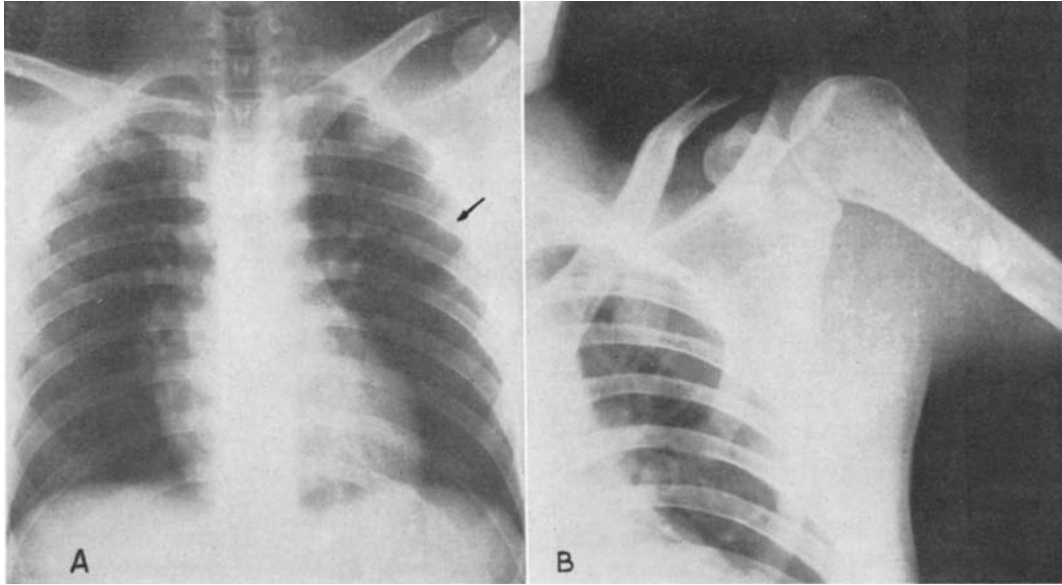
This patient was shot in the chest. A wound of entrance was noted in the left upper thorax. This site was identified roentgenologically because of the powder markings (see arrow in A). The clinician was interested in the location of the bullet and when it was reported that none was demonstrable within the thorax, he was greatly surprised. No wound of exit could be found and therefore further roentgenographic studies were requested. It was then found that the bullet had been deflected from a rib surface into the left axilla, finally to become embedded in the left humerus (B).
